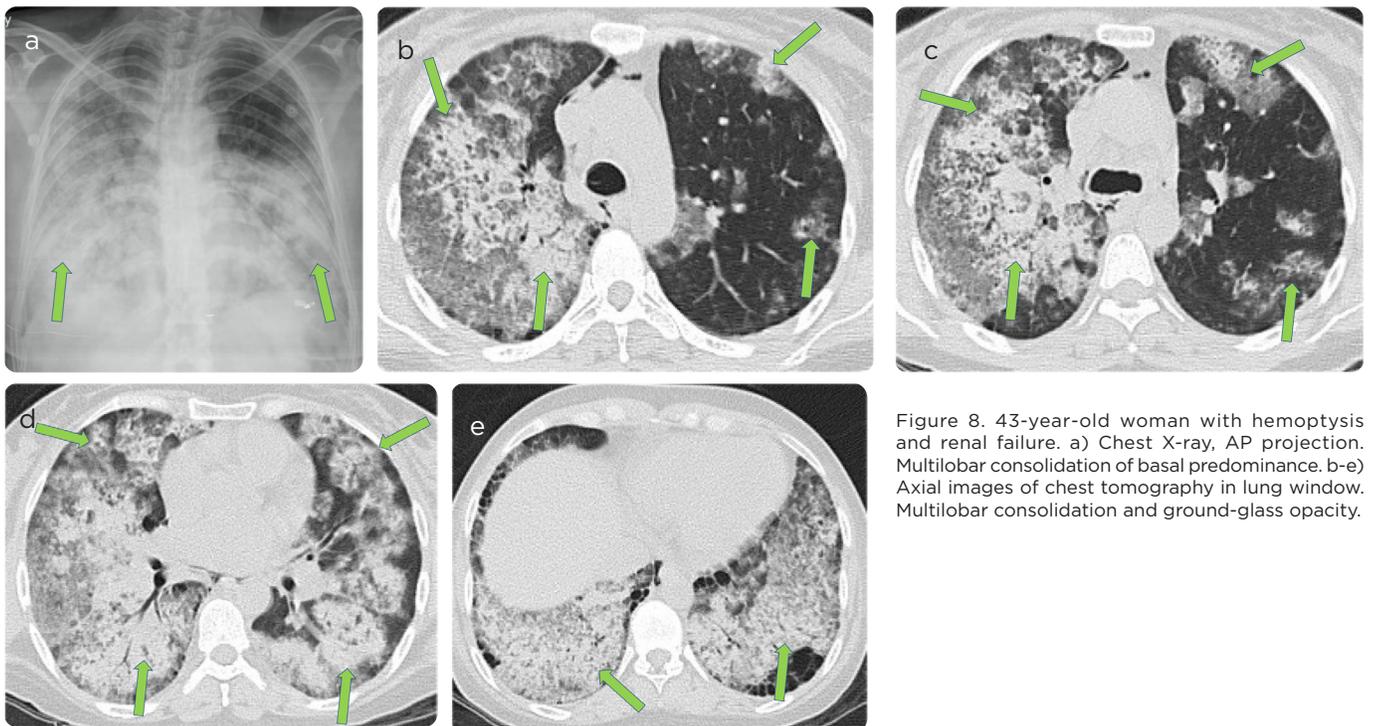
43-year-old woman with hemoptysis and renal failure. a) Chest X-ray, AP projection. Multilobar consolidation of basal predominance. b-e) Axial images of chest tomography in lung window. Multilobar consolidation and ground-glass opacity.
